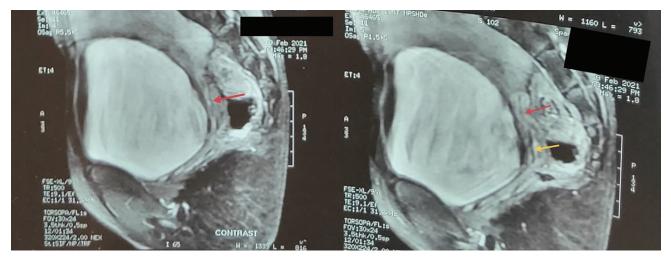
Sagittal cuts of MRI scan of the pelvis of the patient at the age of 16 years. The body of the uterus posterior to the bladder is hypoplastic with a slit-like uterine cavity (*red arrow*). The length of the vagina is normal (*yellow arrow*).
